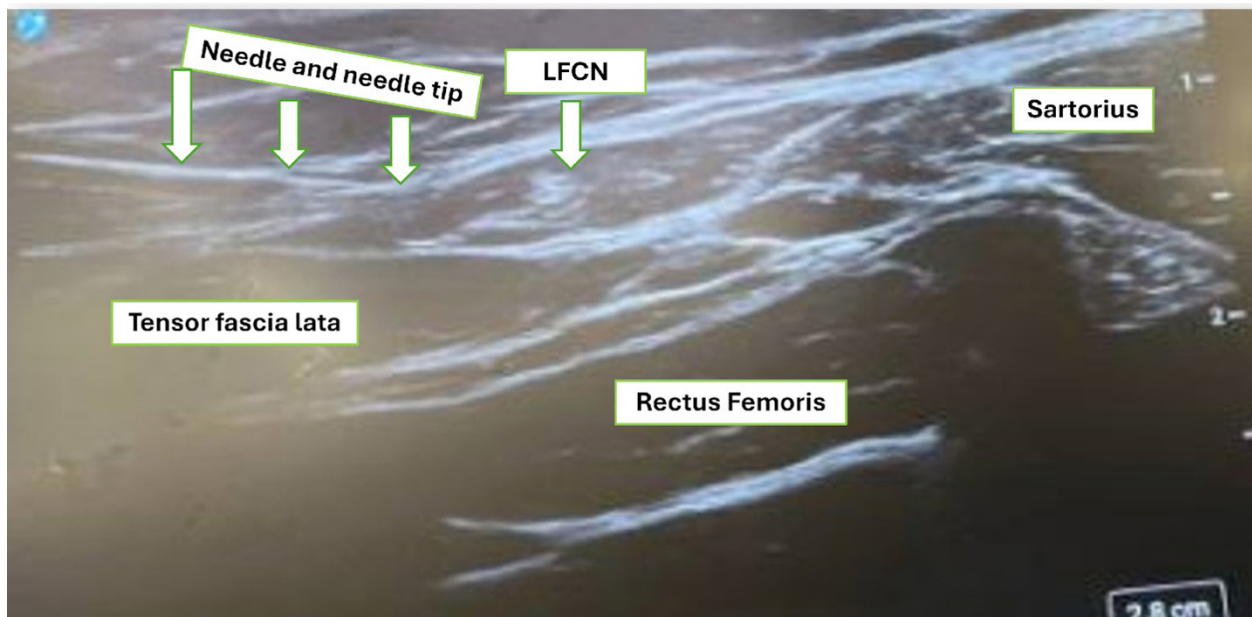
Ultrasound-guided approach to LFCN PNS.
